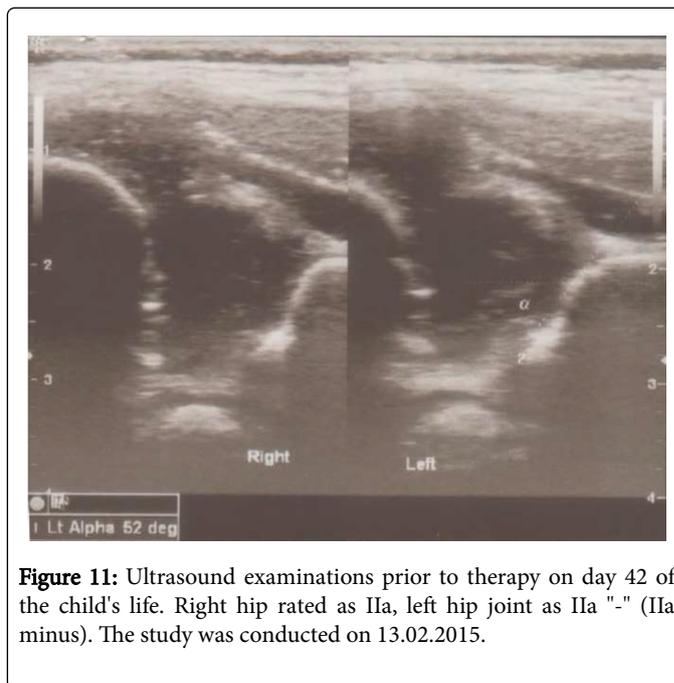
Ultrasound examinations prior to therapy on day 42 of the child's life. Right hip rated as IIA, left hip joint as IIA "-" (IIA minus). The study was conducted on 13.02.2015.
